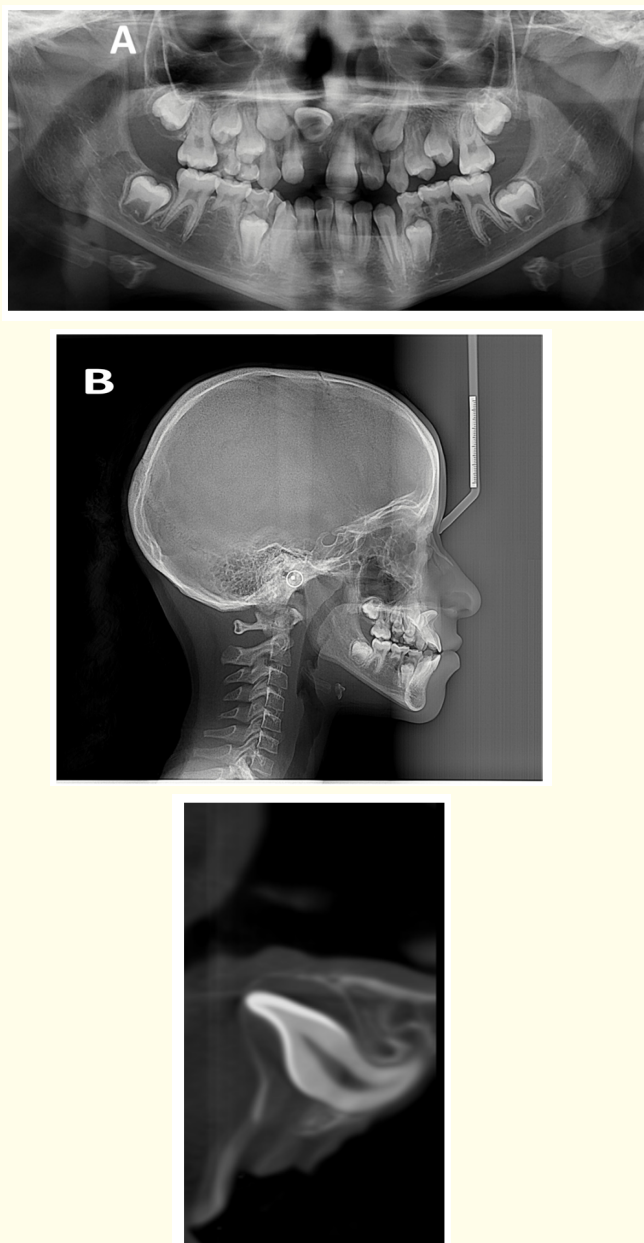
Demonstrates the radiographic records that were made to the patient.
